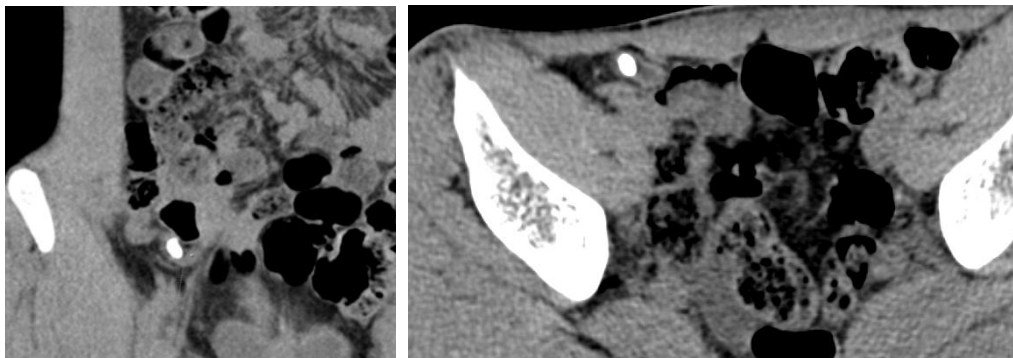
Axial and coronal computed tomography view of the pelvis showing a dilated appendix (white arrow) with appendicolith, and no fluid collection, or abscess
